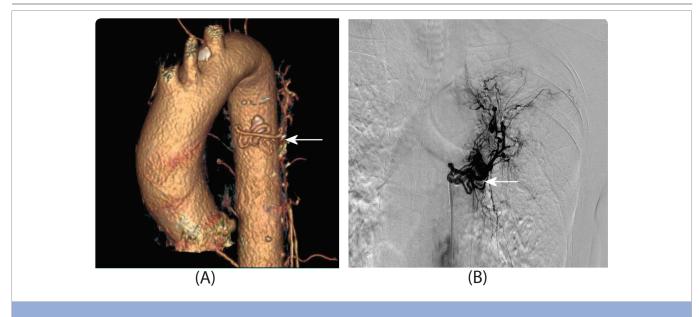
A: three-dimensional CT demonstrates the dilated bronchial racemose hemangioma (BRH) from descending aorta (white allow). B: selective bronchial angiography shows the dilated convolution and pooling of contrast injection in the left upper lobe (white allow).
